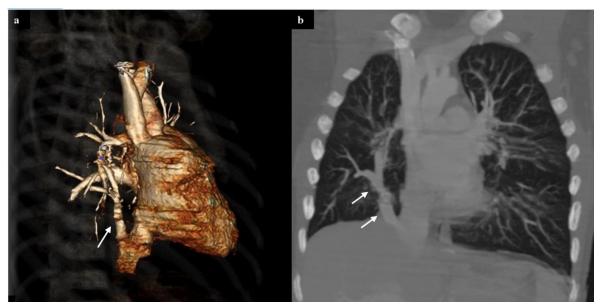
The images of case 4. The images show, a) Scimitar vein 3D Image, b) Scimitar vein coronal plane computed tomography image
